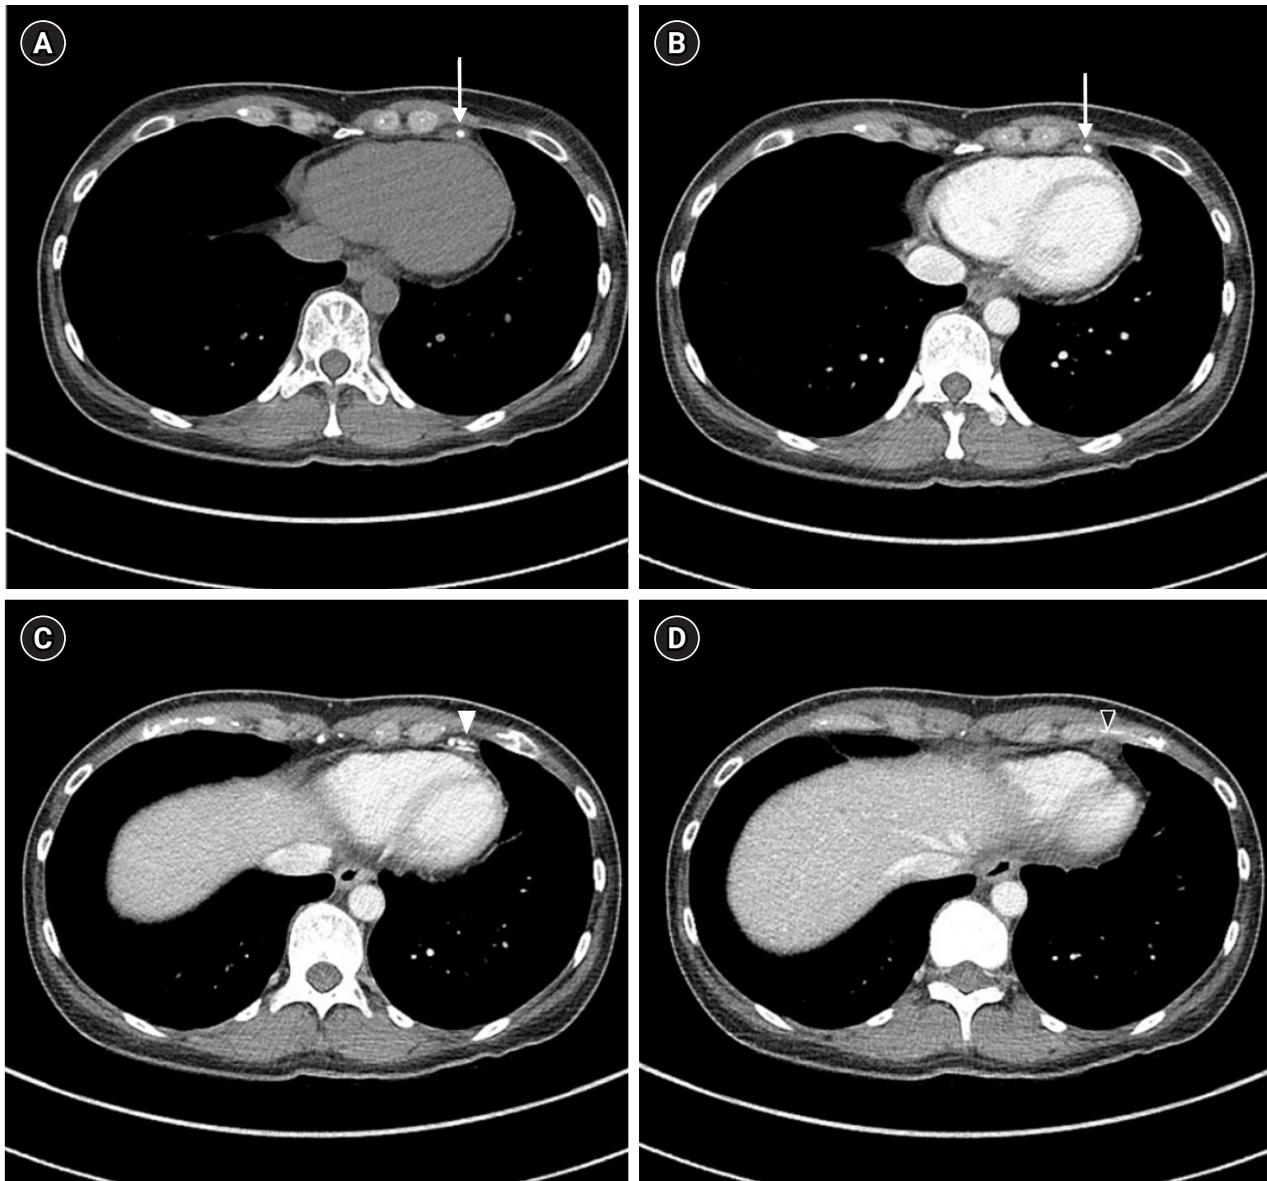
A 32-year-old female patient who presented with acute chest pain one day prior to admission. (A) Non-enhanced chest computed tomography (CT) shows an ovoid soft tissue density nodule with a 6 mm calcification at the left cardiophrenic angle (white arrow). (B–D) Contrast-enhanced axial chest CT scan reveals a 6 mm calcification (white arrow) with peripheral tiny calcifications (white arrowhead) and an enhanced ovoid nodule with soft tissue and fat density (black arrowhead) at the left cardiophrenic angle.
